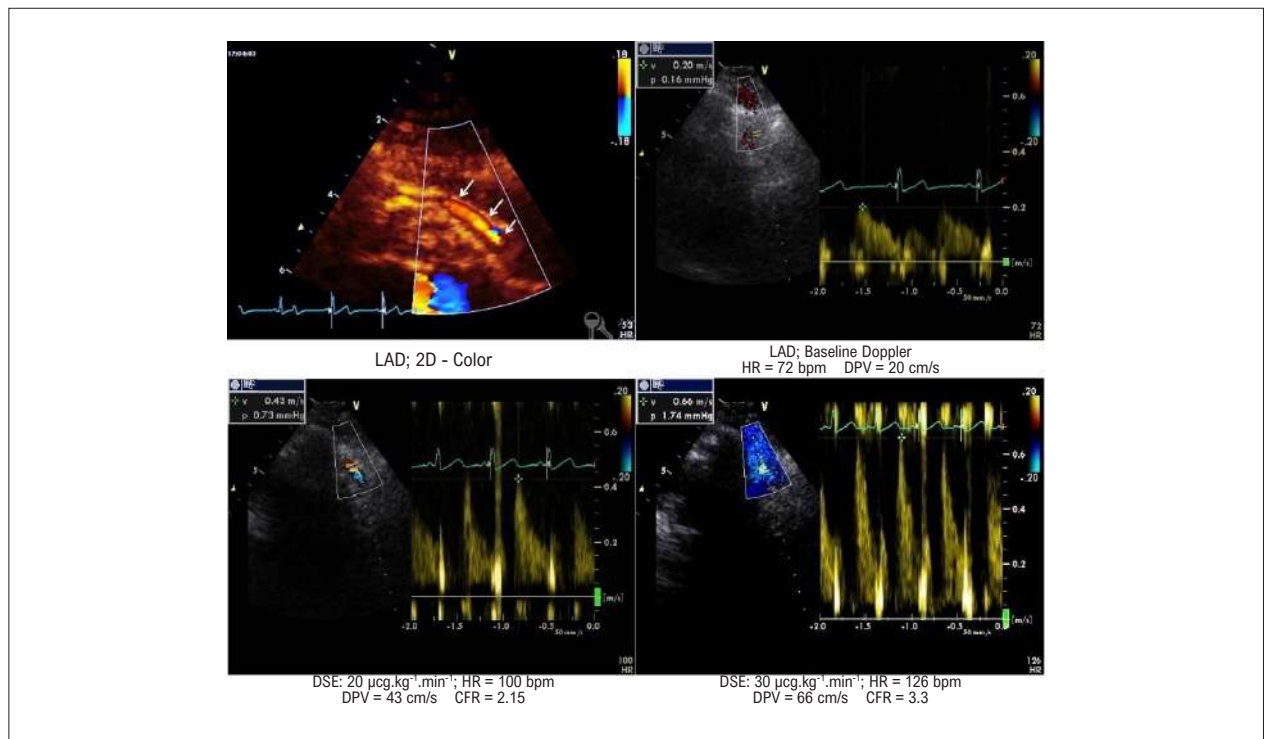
Normal baseline CFR in the left anterior descending artery, increasing significantly (CFR = 3.3) with 30 mcg/kg/min dobutamine. LAD: left anterior descending artery; DSE: dobutamine stress echocardiography; HR: heart rate; DPV: diastolic peak velocity; CFR (coronary flow reserve) = DPV during stress / DPV at baseline. Normal CFR (≥ 2) and early CFR (before reaching the target heart rate of the test), recorded during intermediate stages of DSE.
